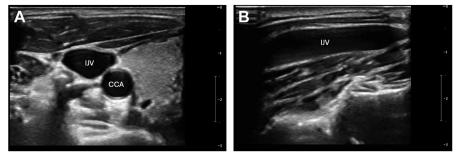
Ultrasound views of the internal jugular vein and common carotid artery visualized in (*A*) short-axis and (*B*) long-axis.
